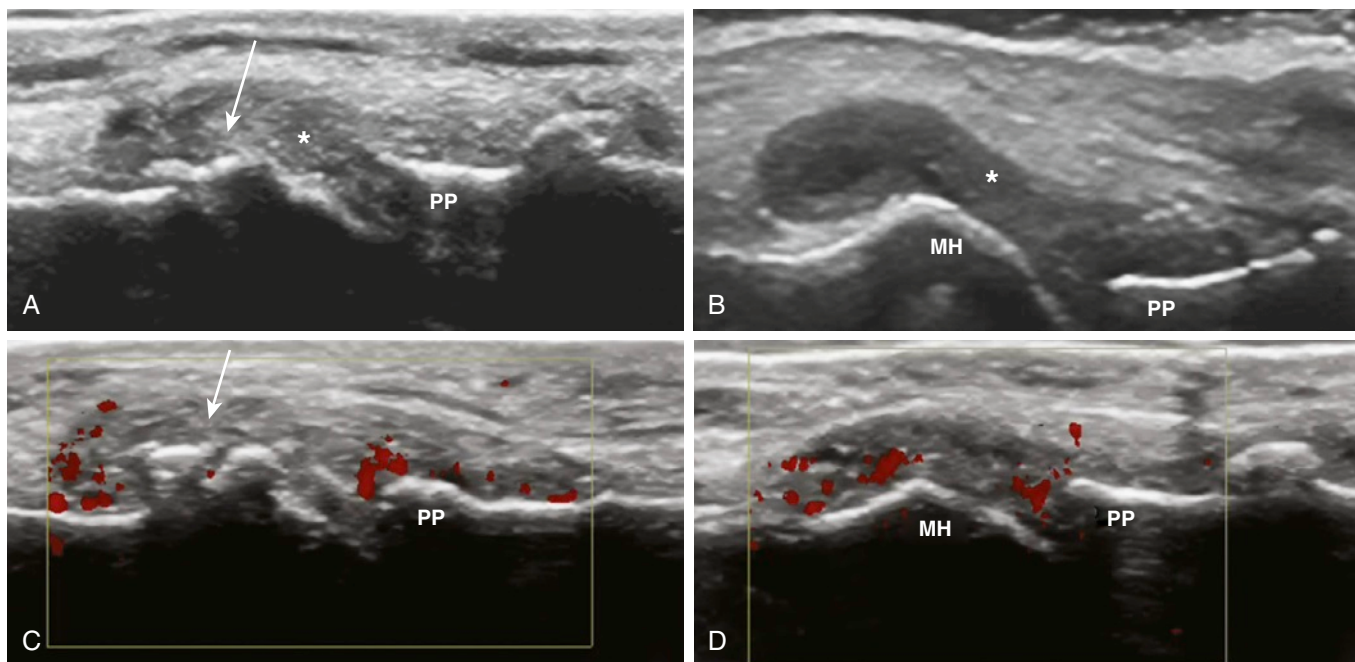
Ultrasound of a foot with osteoarthritis shows involvement of the first metatarsophalangeal joint. A and B, The 15-MHz images demonstrate synovial proliferation (stars) and osteophytes (arrow). C and D, Local active inflammation is demonstrated by the detection of a moderate intra-articular power Doppler signal. MH, metatarsal head; PP, proximal phalanx.
